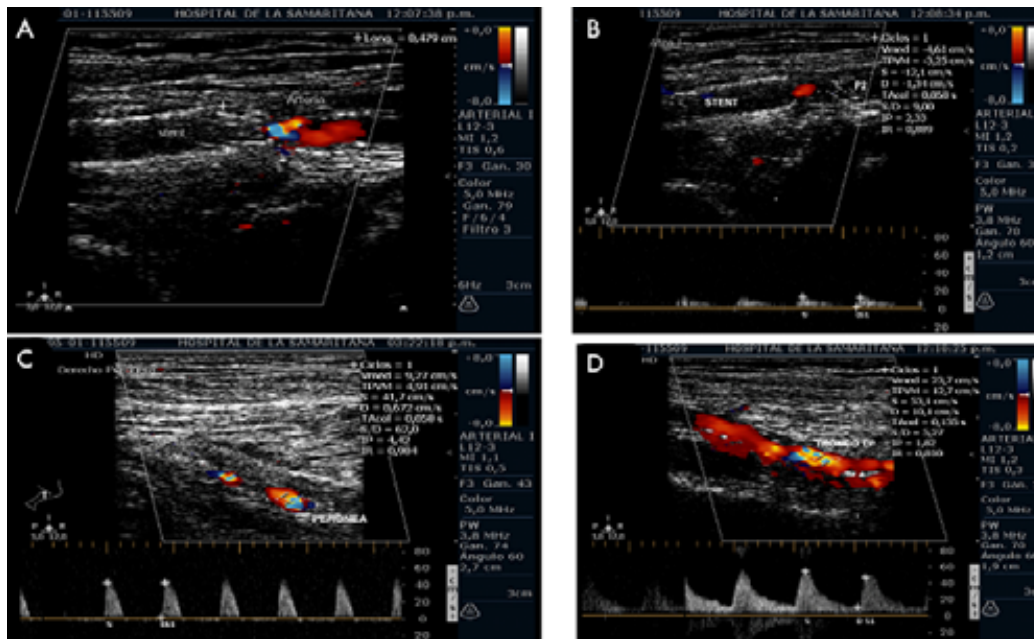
Duplex ultrasound of right lower limb on admission. A) proximal segment of distal popliteal femoral artery stent blocked by hypoechogenic material; B) collateral circulation near the stent in the second segment of the popliteal artery, monophasic flow; C) duplex with biphasic flow in collateral circulation coming from peroneal artery; D) duplex with biphasic flow at the tibiofibular trunk level.
